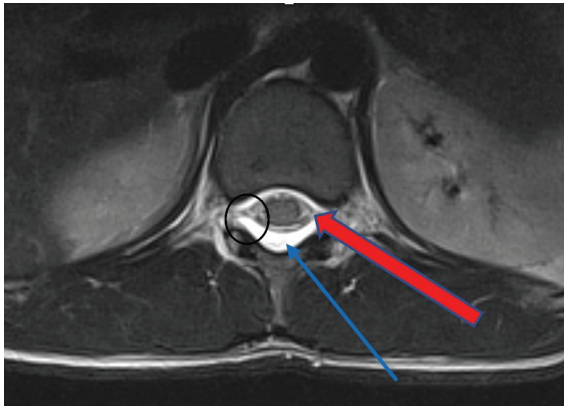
Axial T2 MRI, thoracic region, showed that epidural CSF accumulation (12 hours after lumbar puncture). Red arrow shows dura mater, blue arrow shows epidural space, black circle shows compressed nerve root
